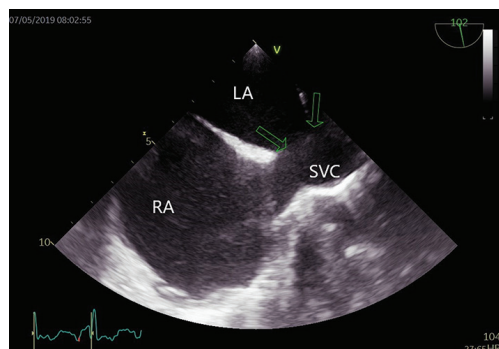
Transthoracic echocardiography. Arrow pointing at a superior sinus venosus atrial septal defect.
